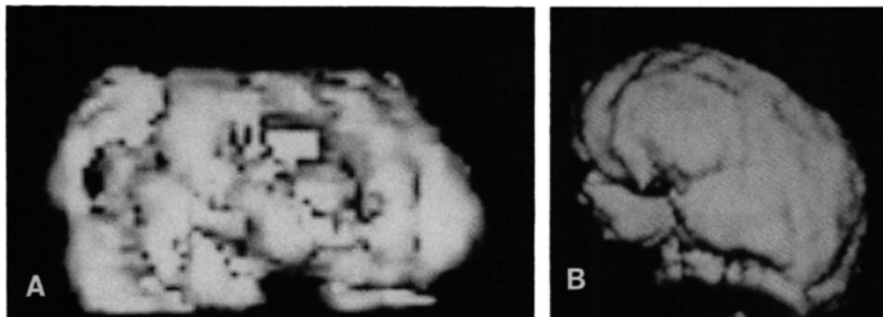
(A) Surface volume FDG image of a patient with Alzheimer's disease showing multiple hypometabolic regions in the parietal, temporal and occipital lobe. (B) In contrast to Figure 6A the rotating volume image of a normal human brain showing a smooth surface and no defects.
